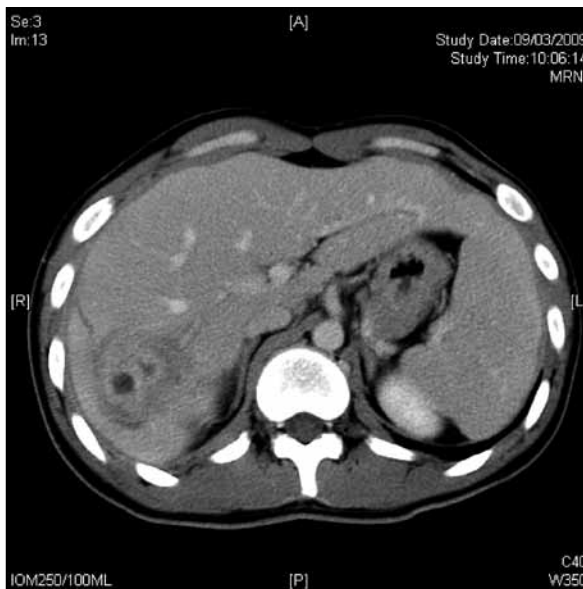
Computed tomographic image showing a rim-enhancing lesion suggestive of residual liver abscess after drainage and vancomycin treatment
